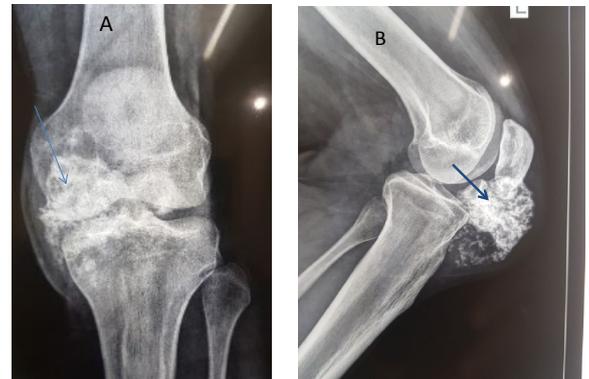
A,B- Anteroposterior and Lateral radiographs of left knee in a 26 yr old male showing a well defined calcified ovoid lesion in Hoffa's fat pad (arrows)
